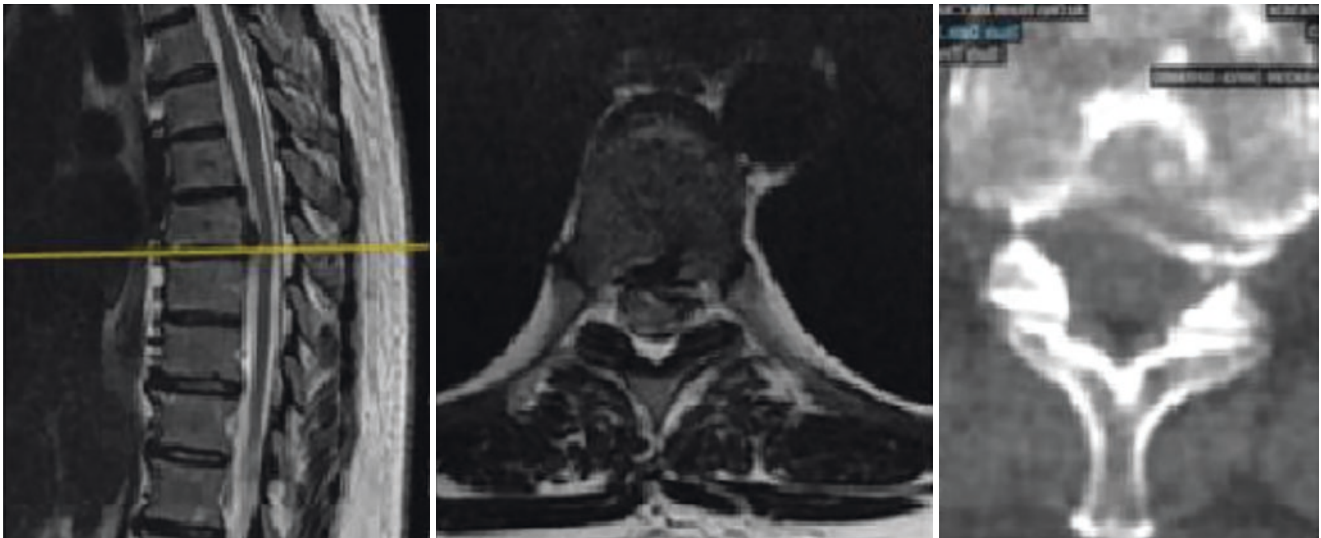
CT scan and MRI preoperative studies showing a mediolateral partially calcified disk herniation
